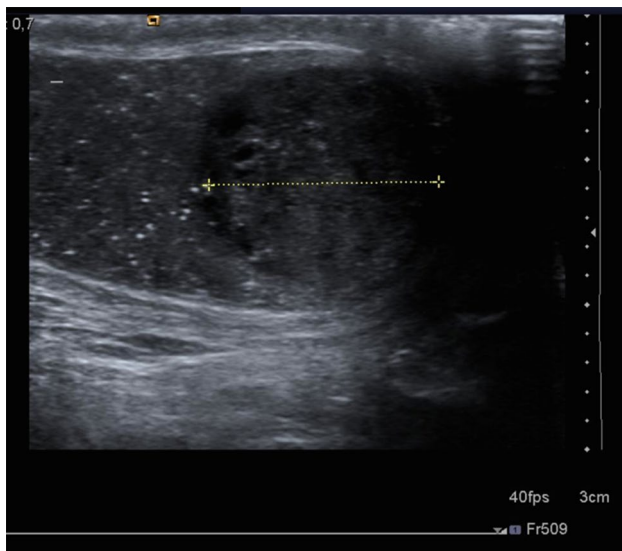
An ultrasonography of a 16-year-old male with testicular cancer and multiple TML diagnosed in 2014 in our Department of Radiology. The longitudinal size of the tumour was 1.6 cm
